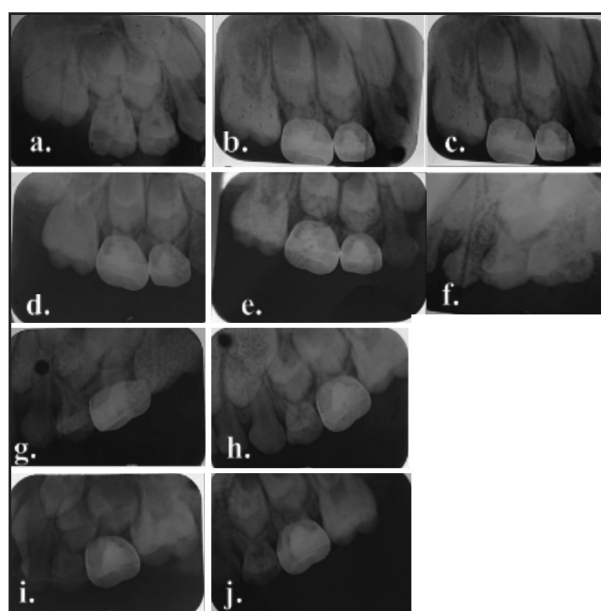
a. Preoperative periapical radiograph showing caries present in upper right first and second primary molars. b. Postoperative periapical radiograph showing upper right first (formocresol) and second (propolis with chitosan mixture) primary molars. c. Periapical radiograph showing upper right first and second primary molars at 1 month follow up. d. Periapical radiograph showing upper right first and second primary molars at 3 month follow up. e. Periapical radiograph showing upper right first and second primary molars at 6 month follow up. f. Preoperative periapical radiograph showing caries in upper Left second primary molar. g. Postoperative Periapical radiograph showing upper left second (propolis) primary molar. h. Periapical radiograph showing upper left second primary molar at 1 month follow up. i. Periapical radiograph showing upper left second primary molar at 3 month follow up. j. Periapical radiograph showing upper left second primary molar at 6 month follow up.
